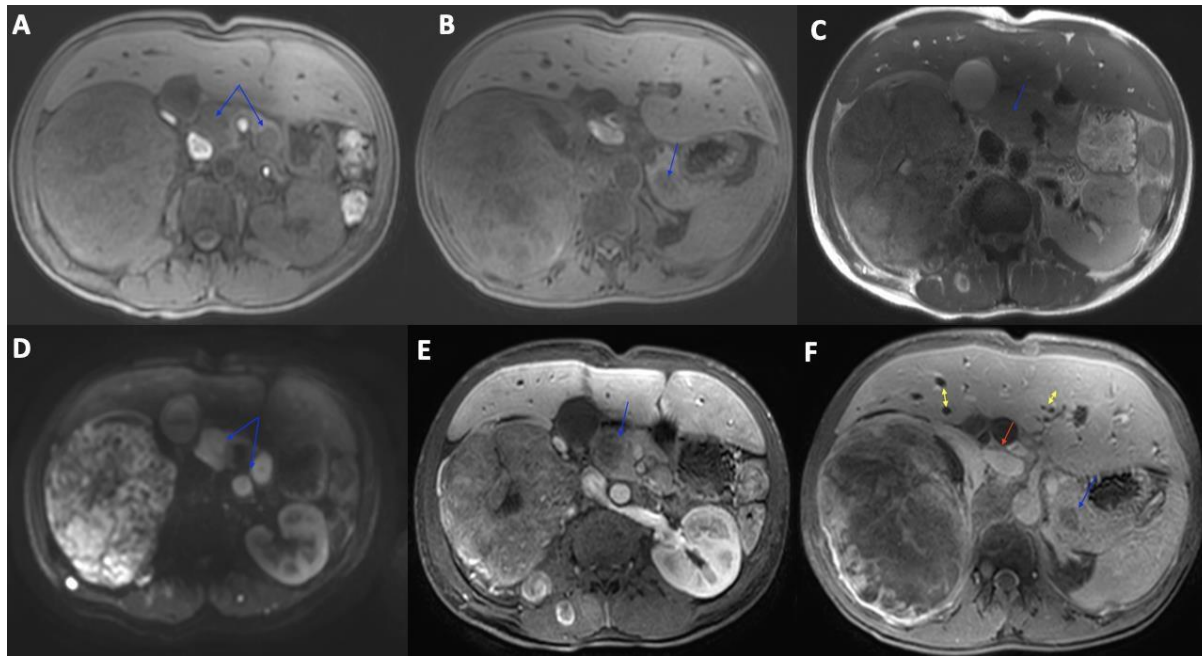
Axial MRI images depict several pancreatic lesions (blue arrows), appearing hypointense on T1-weighted sequences (A, B) and isointense on T2-weighted sequences (C), hyperintense on diffusion-weighted imaging (DWI) (D) and show no enhancement after gadolinium injection (E, F). Notably, the lesion in the cephalic region causes compression of the lower choledochus, leading to dilation of the common bile duct (red arrows) and the intrahepatic bile duct (yellow arrows) (F).
